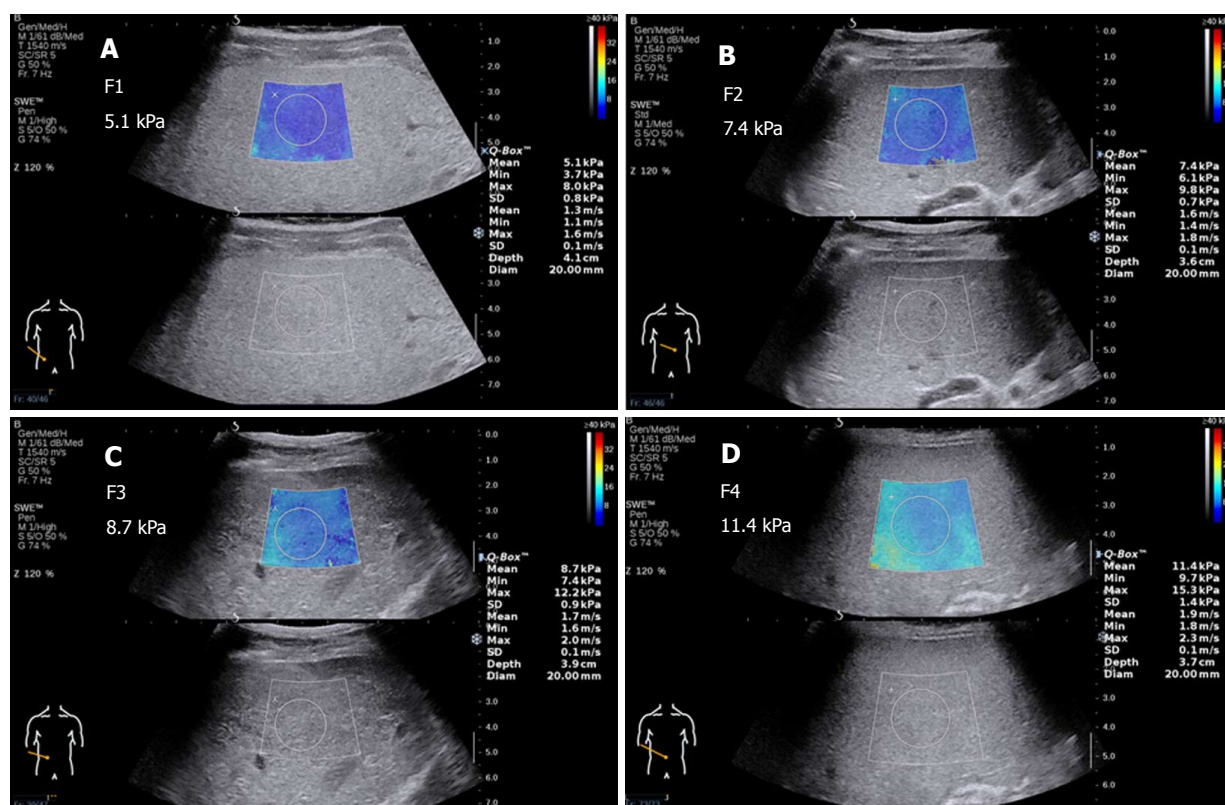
Two-dimensional shear wave elastography (Aixplorer US system, SuperSonic Imaging, France) of the liver in chronic hepatitis B patients with liver biopsy-proven fibrosis at METAVIR stages F1 through F4. A: F1 stage, mean Young's modulus = 5.1 kPa, mean shear wave velocity = 1.3 m/s; B: F2 stage, mean Young's modulus = 7.4 kPa, mean shear wave velocity = 1.4 m/s; C: F3 stage, mean Young's modulus = 8.7 kPa, mean shear wave velocity = 1.7 m/s; D: F4 stage, mean Young's modulus = 11.4 kPa, mean shear wave velocity = 1.9 m/s. Note the liver stiffness gradually increases, and the color of the sampling frame gradually changes in the initial stages and incrementally increases in the later stages of fibrosis. 2D-SWE: Two-dimensional shear wave elastography; US: Ultrasound.
